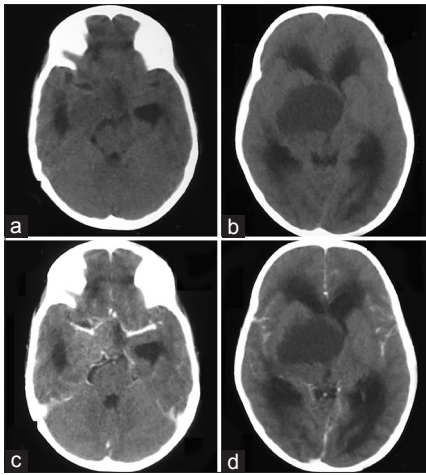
(a and b) Noncontrast preoperative head computed tomography (CT) scan showed isohypodense mass at suprasellar region that extends into parasellar region and third ventricle; an acute obstructive hydrocephalus was shown. (c and d) Postcontrast preoperative head CT scan showed inhomogeneous enhancement of the mass at suprasellar region (c) Mass size was measured 5 cm × 5 cm × 4 cm
